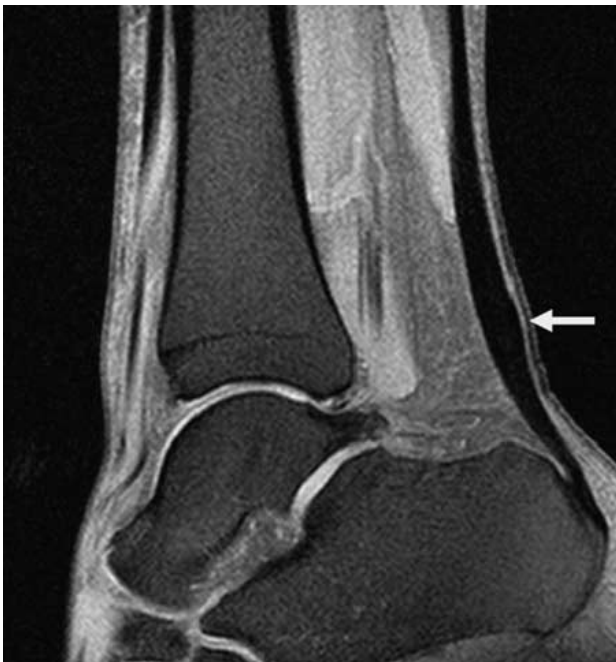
Magnetic resonance imaging showing tendinopathy of the main body of the Achilles tendon.
